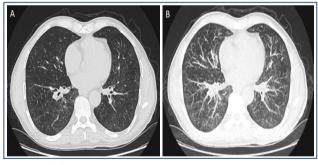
(A) In a 57-year-old male patient with a 35 packs/year smoking history, ill-defined centriacinar nodules were detected on a conventional axial computed tomography scan. (B) Centriacinar nodules are more demonstratively observed in the maximum intensity projection images of the same patient.
